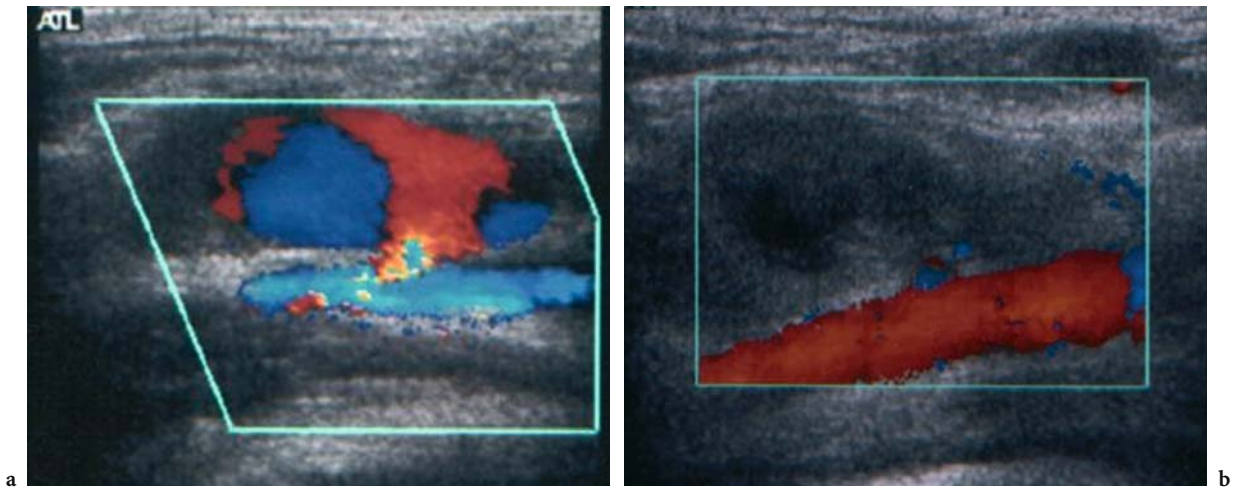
A 10-year-old boy with a pseudoaneurysm of the femoral artery related to cardiac catheterization. a Color ultrasonography shows the presence of a pseudoaneurysm. b Under ultrasonography, direct puncture of the pseudoaneurysm was performed with a 22-G Cathlon. 800 units of Thrombostat permit to occlude the pseudoaneurysm
